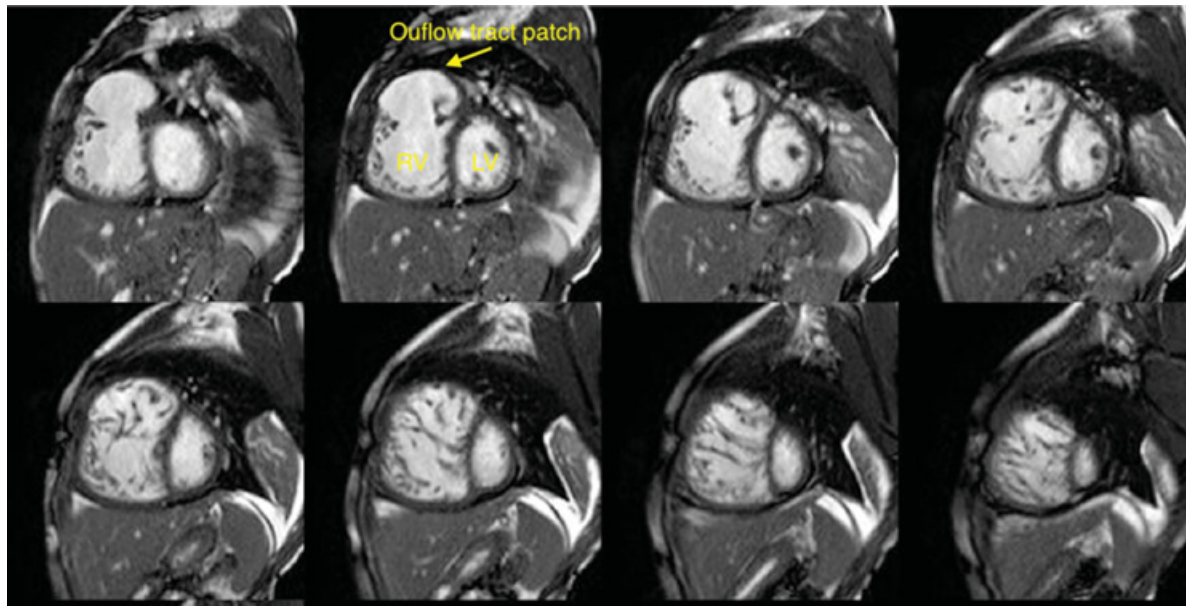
Tetralogy of Fallot. Short axis magnetic resonance imaging stack showing markedly dilated right ventricle with a dilated outflow tract patch after repair of TOF. Chronic pulmonary regurgitation results in a dilated RV and eventually leads to RV dysfunction. The RV dilation and dysfunction can lead to tricuspid regurgitation, arrhythmias and rarely sudden death. Courtesy of Michael Taylor, MD.
